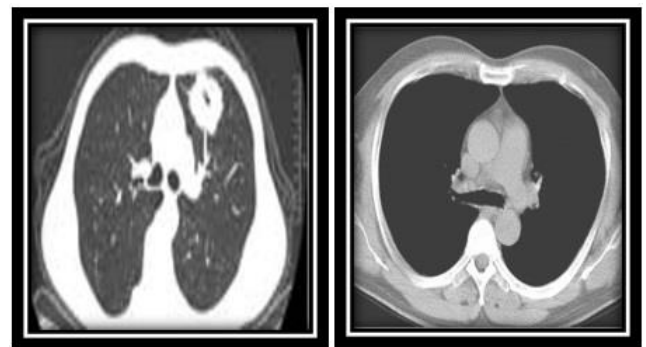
(Left) CT image of the lung of an individual infected with Covid 19 virus and (right) CT image of the lung of a healthy individual
